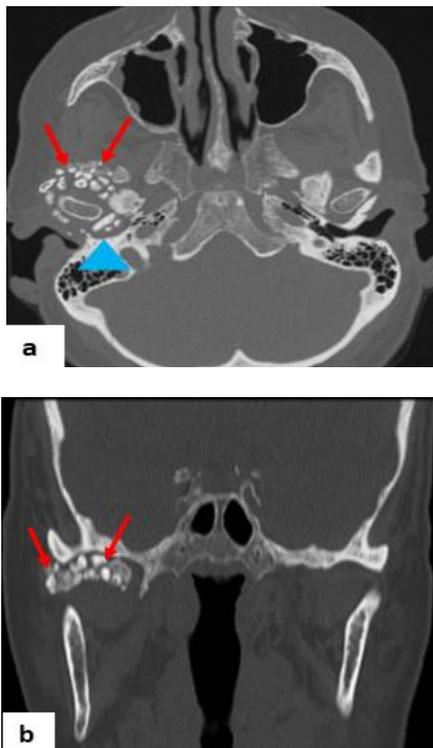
axial (a) and coronal (b) CT image showing multiple ossified bodies (Red arrows) in the right TMJ and erosion of the glenoid fossa (Blue arrowhead) without endo-cranial extension.
